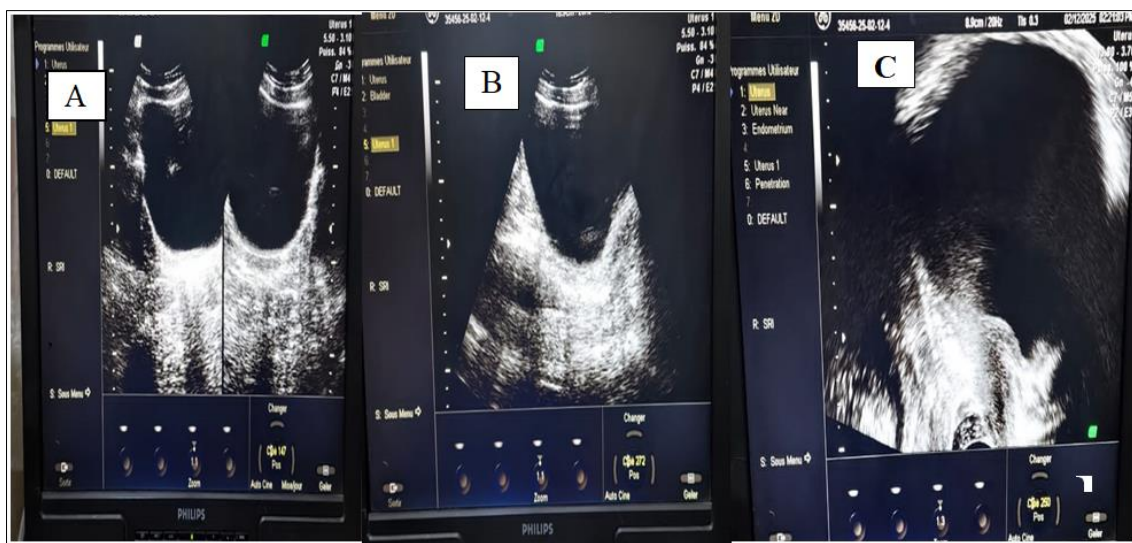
Endo-vaginal and supra-pubic pelvic ultrasound (A, B and C) showing a well-filled bladder without visualization of the uterus or ovaries
